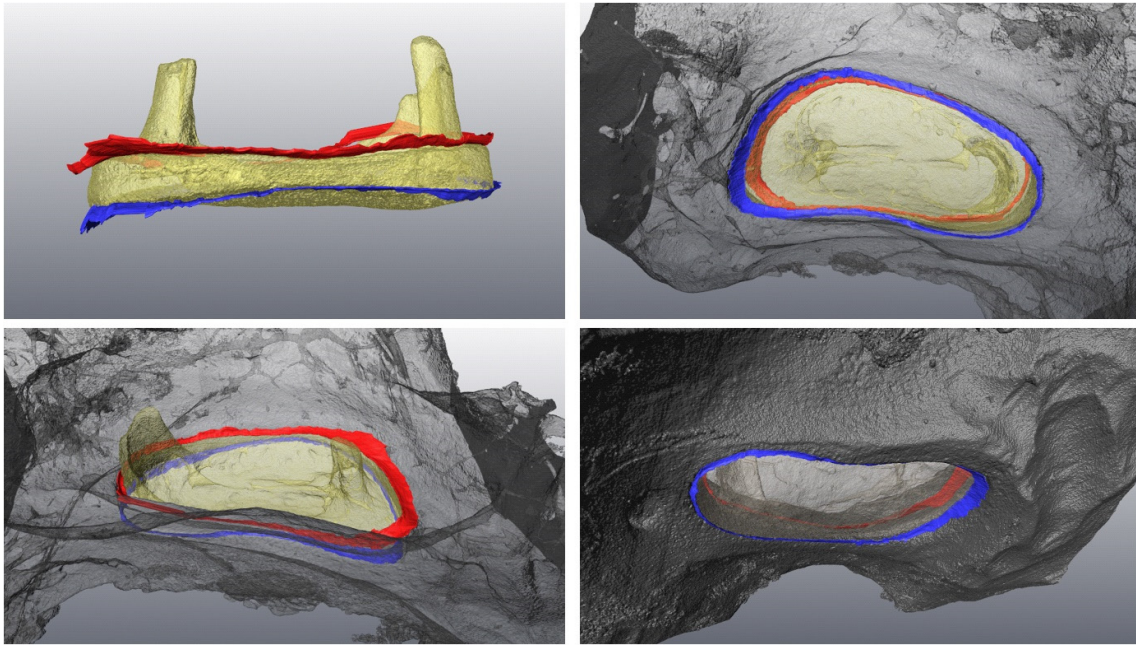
Segmented face layers (the middle-ear side in red and the cochlear side in blue) after registration to the segmented stapes and peripheral bones from the μ CT images.
